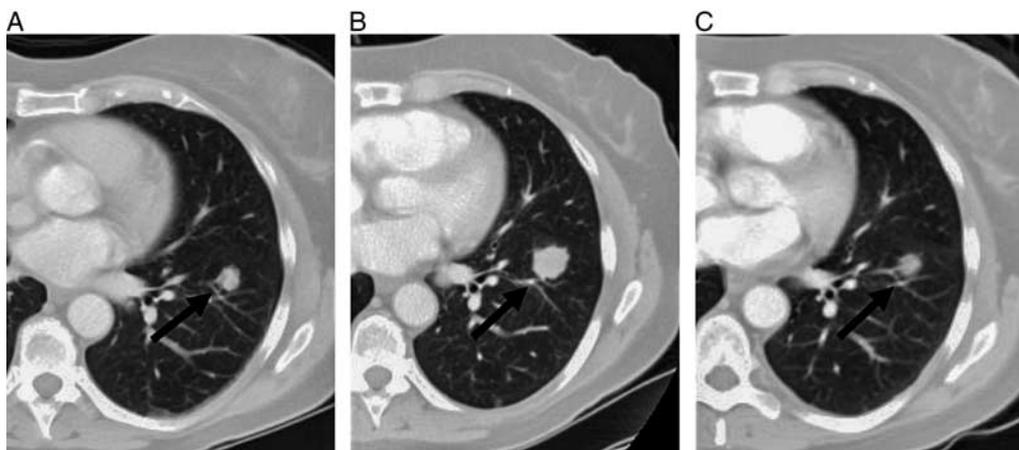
Pseudoprogression: an increase in tumor burden, initially after immunotherapy is commenced, with a subsequent reduction in tumor burden, often followed by a partial or complete response, as defined by the RECIST criteria. A, Baseline axial CT before commencing immunotherapy showing a left upper lobe tumor (arrow). B, Axial CT, 2 months after initiation of immunotherapy, shows increased size of the nodule, which, using RECIST 1:1 criteria, would be deemed progressive disease. C, Axial CT obtained 8 weeks later with the patient remaining on immunotherapy now demonstrates a reduction in size of the nodule, consistent with treatment response.
